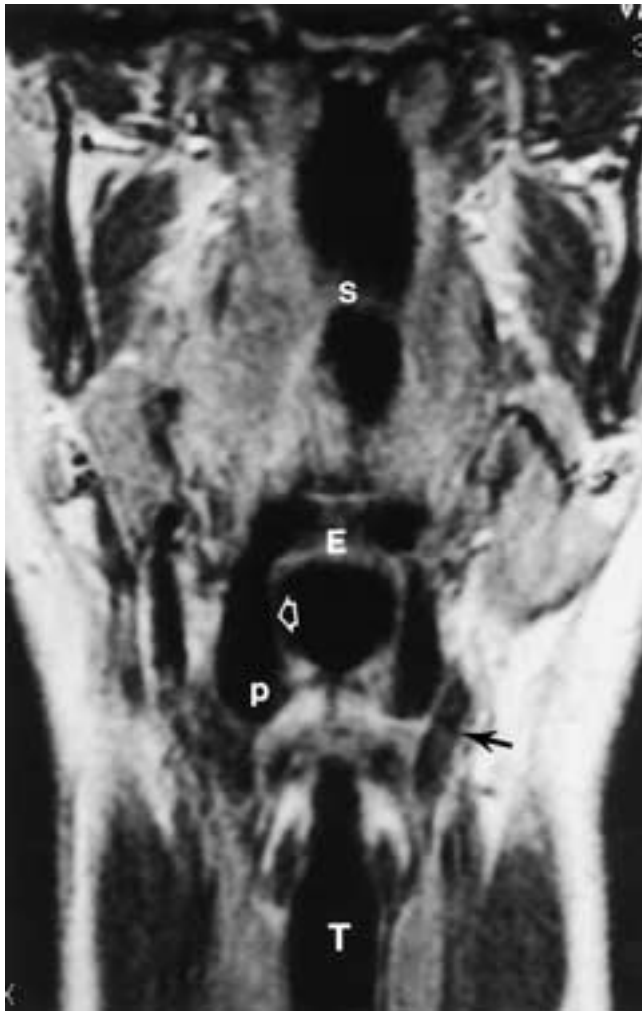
Coronal T1-weighted MR image after gadolinium administration shows the pyriform sinuses (*p*), epiglottis (*E*), aryepiglottic folds (*open arrow*), thyroid cartilage (*solid arrow*), soft palate (*s*), and trachea (*T*).
